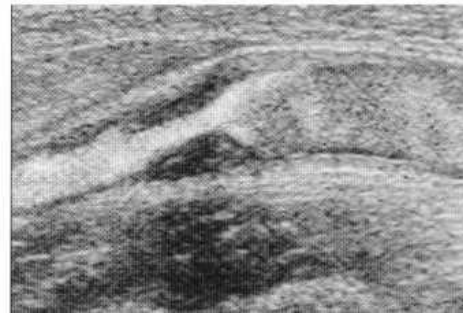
A 'B flow' image of an internal carotid artery stenosis with the echoes from the moving blood clearly shown in the lumen of the vessel. (Courtesy of GE Ultrasound.)
